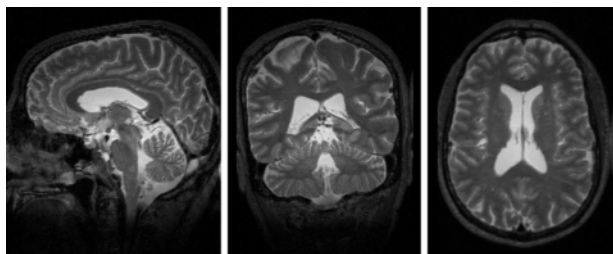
T2-weighted sagittal, coronal and axial 3-T brain images from a healthy volunteer. The three 1-mm thick images were all reconstructed from the same 3D acquisition.
